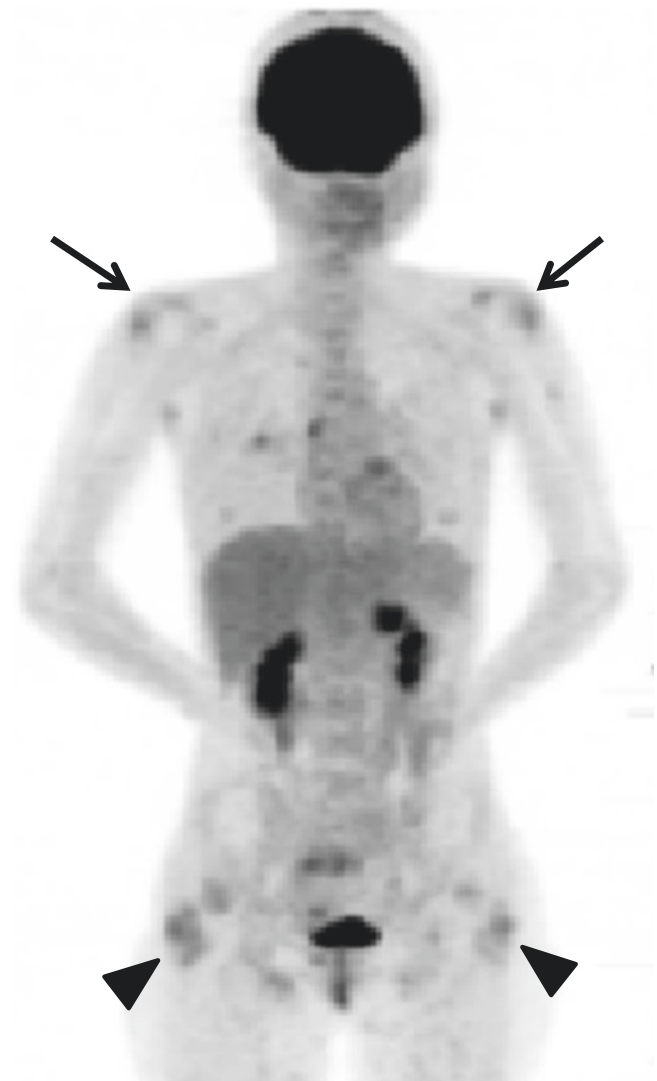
MIP image showed multiple FDG uptakes in the bilateral deltoid muscles (arrow), bilateral gluteus maximus muscles (arrow head)
